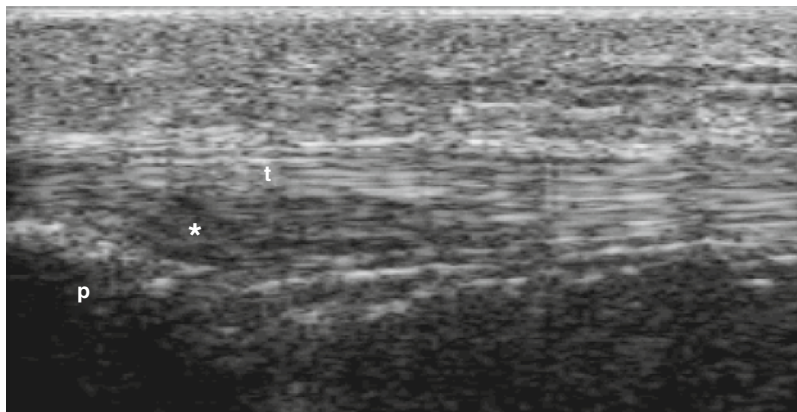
Ultrasound identifies paratenonitis (*star*) of the patellar tendon (t). p, patella (distal part).
